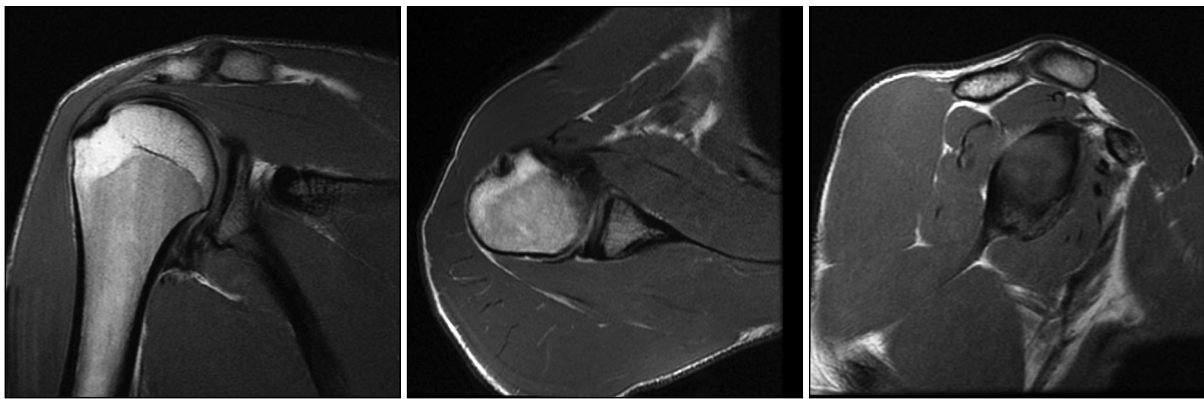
Magnetic resonance imaging of the shoulder joint with glenoid deficiency.
